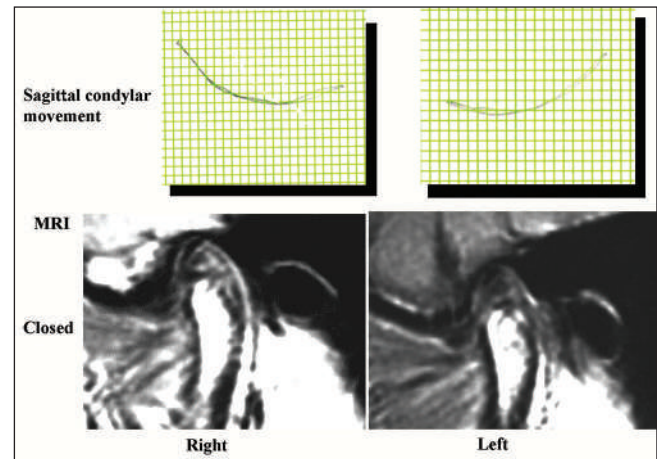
Sagittal condylar movement and magnetic resonance images after treatment (36Y 2M)
